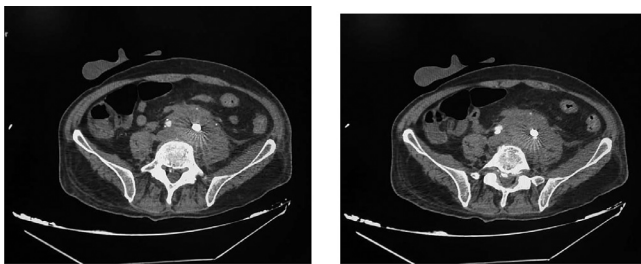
Contrast-enhanced CT scan 1 month later shows no evidence of contrast extravasation or endoleak signs.
